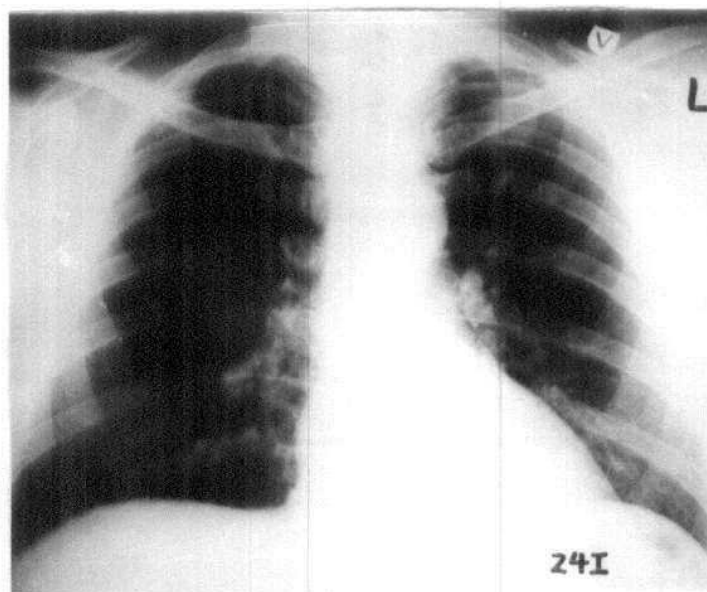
Preoperative chest radiograph for patient No. (24 I): No active lung lesion.
